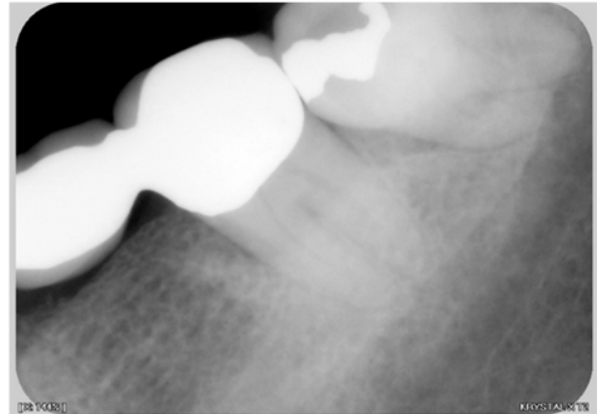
(b) Lower left side PA radiograph of deceased's dentition. The teeth 35-37 bridge, and the distinctive morphology of the tooth 38 metallic restoration correspond to the antemortem radiograph.
